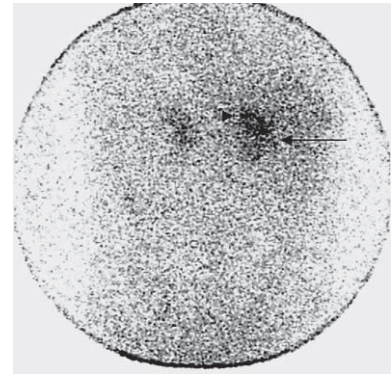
^{131}I -adosterol scintigraphy showed high uptake in the right adrenal gland (). The uptake in the upper portion of the right adrenal gland was predominately high (►). The uptake in the left adrenal gland was within normal limits.
